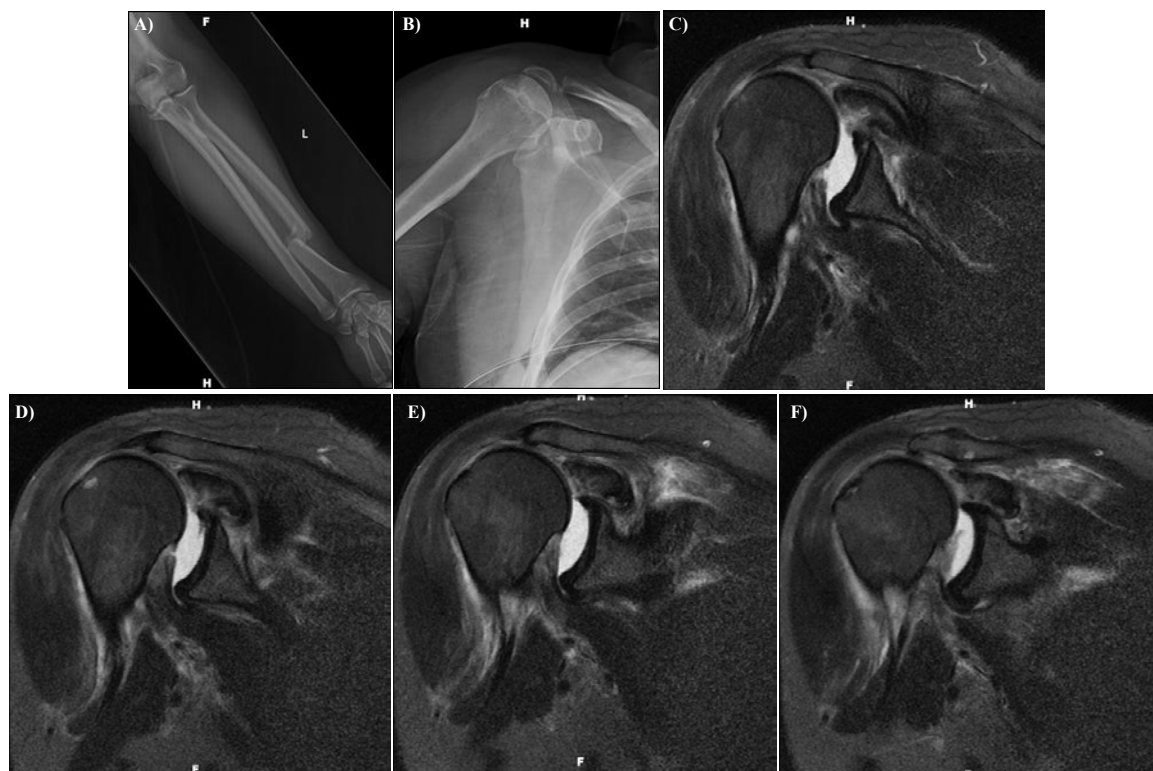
Patient A, a 51 year old male, was involved in a motorcycle accident, sustaining numerous traumatic injuries including liver and renal lacerations, a pneumothorax requiring a chest tube, rib fractures, and fractures of his left hand and a) left distal radius. The patient complained of pain in his right shoulder but b) radiographs were obtained and read as normal. Undiagnosed at the time of the patient's initial hospitalization was a rotator cuff injury. After healing of his fractures 2 months post injury, the patient was referred to our clinic for persistent right shoulder pain and decreased range of motion. An MRI was obtained which revealed c-f) a massive rotator cuff tear.
